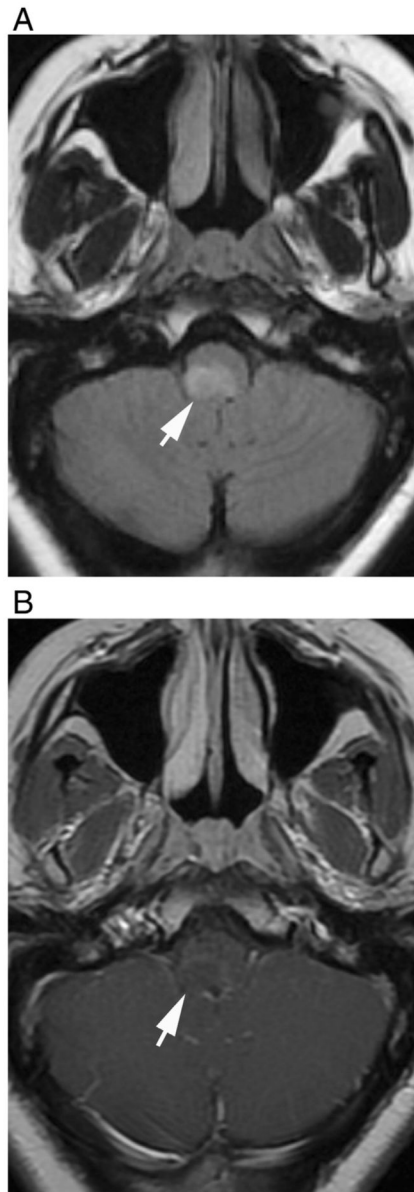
Periependymal linear enhancement. (A) Axial fluid-attenuated recovery and (B) T1-weighted contrast-enhanced images show thicker periependymal enhancement in a 73-year-old male during ON attack later in the course of the disease.
